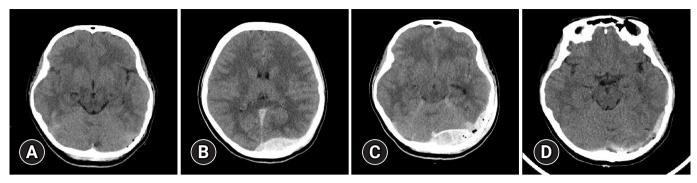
Computed tomography (CT) scans of case 3. (A) Initial axial CT scan demonstrates a thin layer of subdural hematoma in the left temporal convexity without epidural hematoma. (B) Follow-up CT scan shows the supratentorial portion of an acute left supratentorial and infratentorial extradural hematoma. (C) Follow-up CT scan indicates the infratentorial portion of an acute left supratentorial and infratentorial extradural hematoma, along with increased subdural hematoma in the left temporal convexity. (D) Postoperative axial CT scan reveals no complications.
